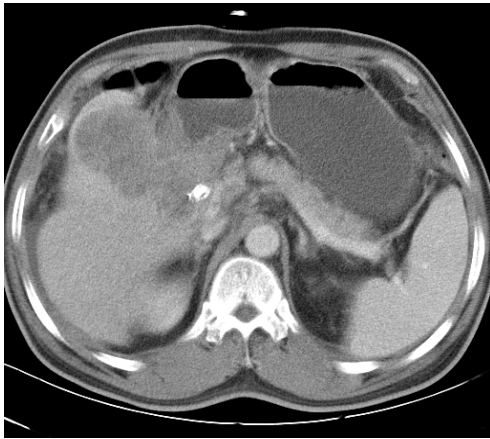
Axial CT scan shows invasion of recurrent GB cancer into 1st and 2nd portion of duodenum.
